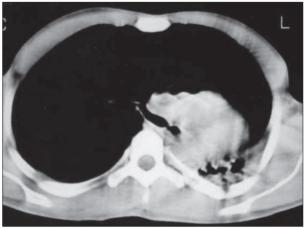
Computed tomography showed hypoplasic left lung.
